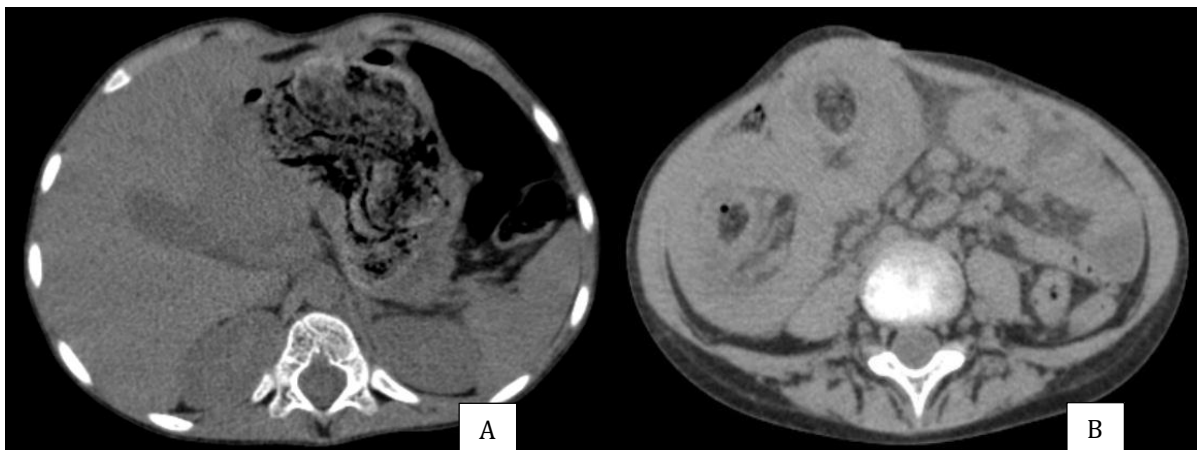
Axial computed tomography. (A) view showing heterogeneous mass in the stomach consistent with a bezoar. (B) view with evidence of small bowel to small bowel intussusception.
